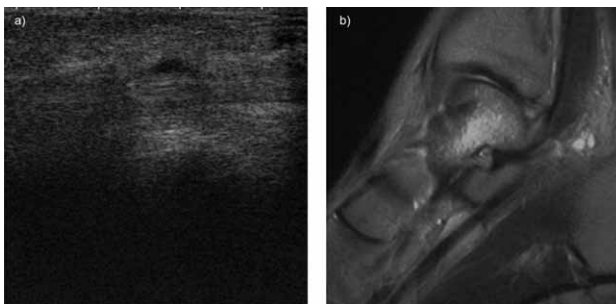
a) (Ultrasound). Stretching (Lesion G1) of the left Short peroneal muscle tendon; 4.b) (Magnetic resonance). Stretching (Lesion G1) of the right Short peroneal muscle tendon.
